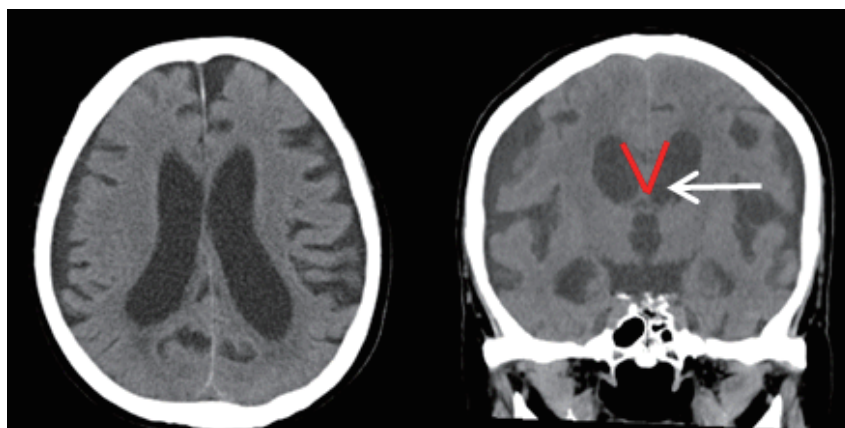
Computed tomography images showing narrowing of the brain groove at the area of high convexity, with a steep callosal angle of 52.5° (arrow) and mild enlargement of the sylvian fissure
